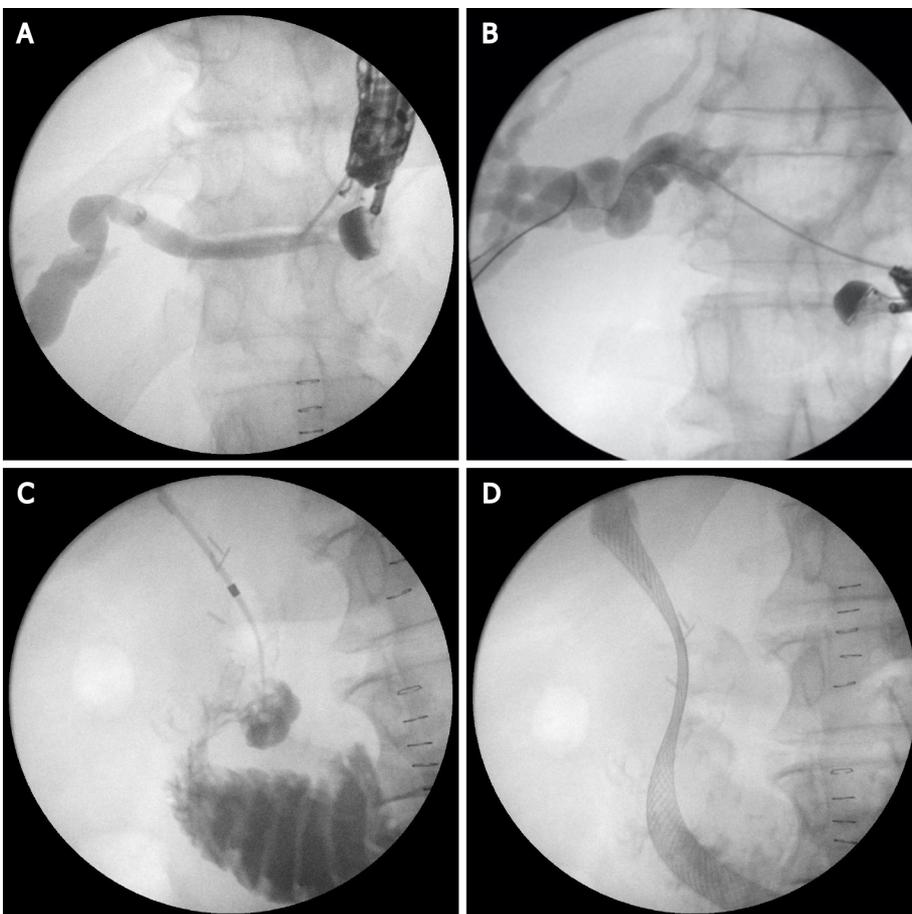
Endoscopic ultrasound-guided antegrade stenting. A: Left hepatic duct puncture with 19G needle; B: Guide-wire insertion; C: Tract dilatation and advancing the biliary catheter tip transpapillary in the duodenum; D: Self-expandable metal stent placement.
